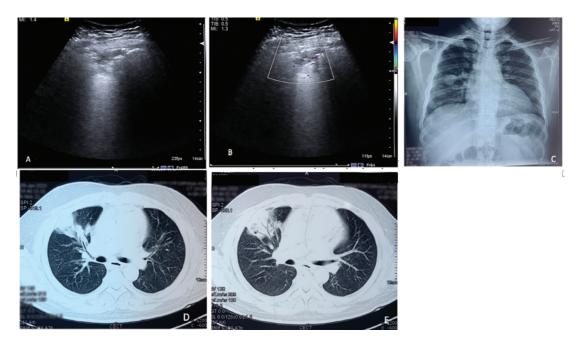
(A and B): Longitudinal gray scale ultrasound scans in a 34-year-old chronic intravenous drug abuser revealed a wedge shaped area of 'tissue like' echotexture with shredded deeper margin in (A) anterior and (B) anterolateral chest wall. Color doppler showed reduced vascularity in the lesion. (C) Chest X-ray in the patient was reported as consolidation. The patient had history of chronic deep venous thrombosis in right axillary and brachial vein with subsequent pulmonary embolism in previous CT scans and was treated for the same before presenting to us. (D and E) CECT chest revealed subpleural wedge shaped areas of consolidation showing air bronchograms in right lung parenchyma, corresponding to the lung zones showing the consolidation on ultrasound. A diagnosis of pulmonary infarct was thus made.
